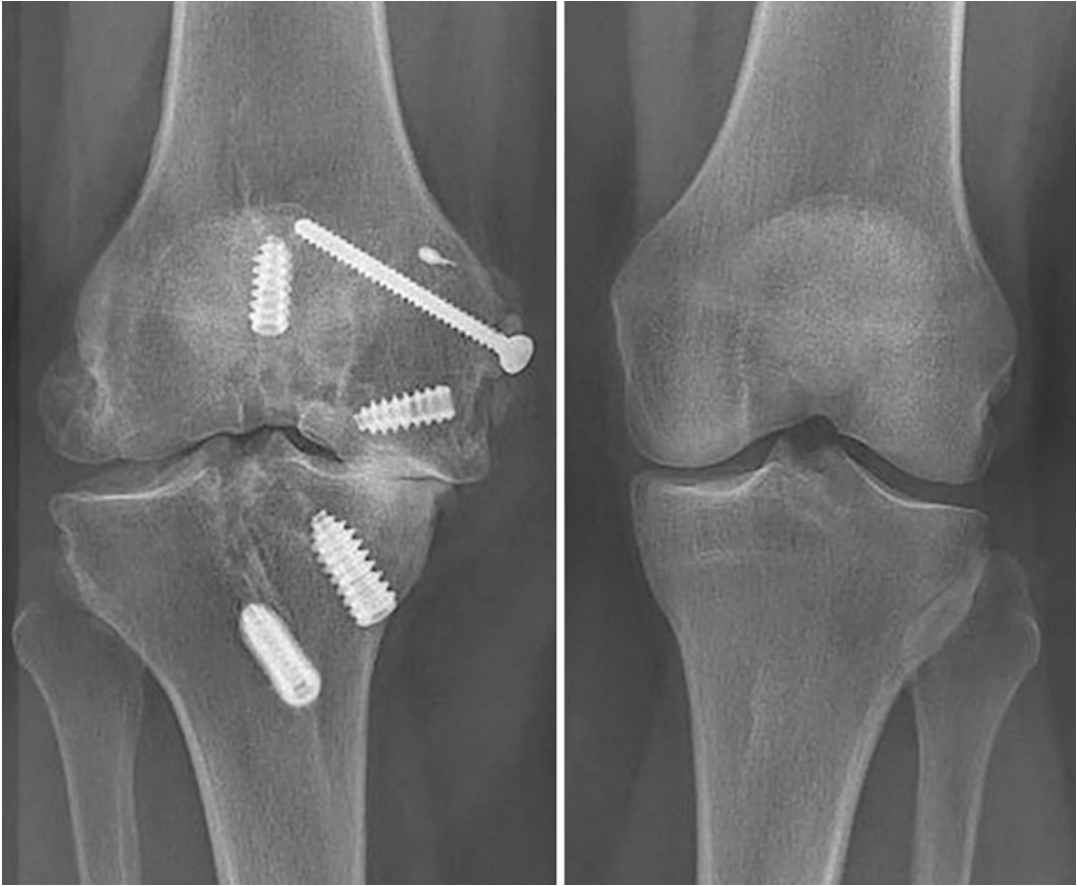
A plain radiograph showing posttraumatic osteoarthritis on the right knee after knee dislocation surgery involving the ACL, PCL, and sMCL. The injured left
